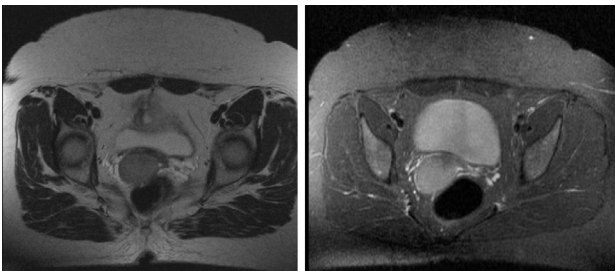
Axial MRI section of the pelvis showing an expansive lesion in the cervix, with a cleavage plane with the bladder and rectum.
